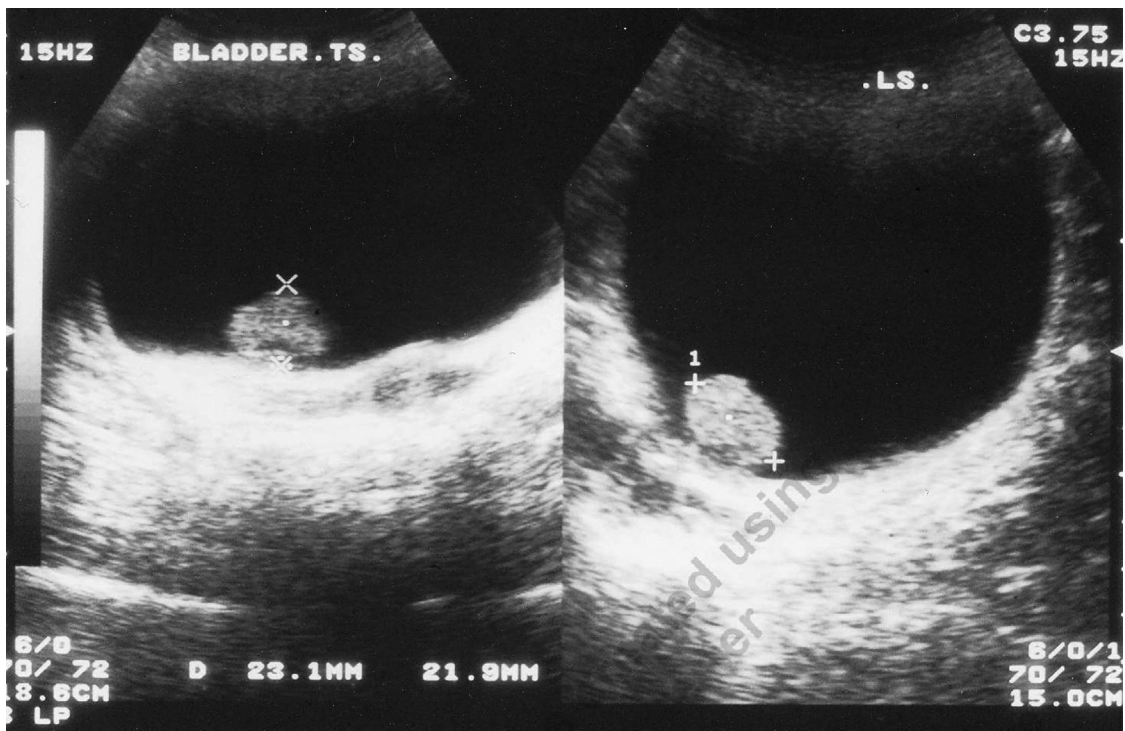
Ultrasound picture showing the filling defect in the bladder.
